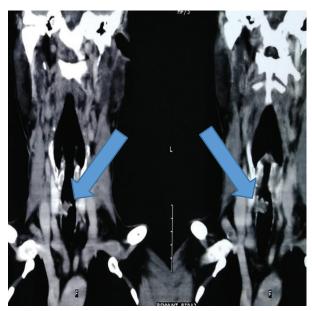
CT Coronal view
